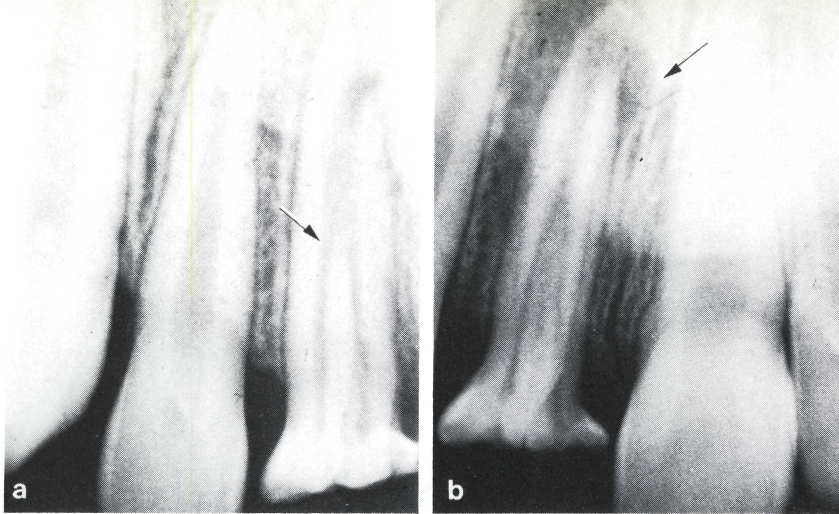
Periapical radiographs of the maxillary right central incisor reveal the dens invaginatus to be of the type 2 variety. a) The invagination (arrow) may be seen to extend to approximately one-half the total root length. The apex of the root appears to be poorly formed with a wide-open foramen. b) A periapical radiolucency (arrow) may be seen in this radiograph, indicating that pulp inflammation and degeneration have occurred. The retardation in root formation is apparent, when the root lengths of the right and left central incisors are compared.
